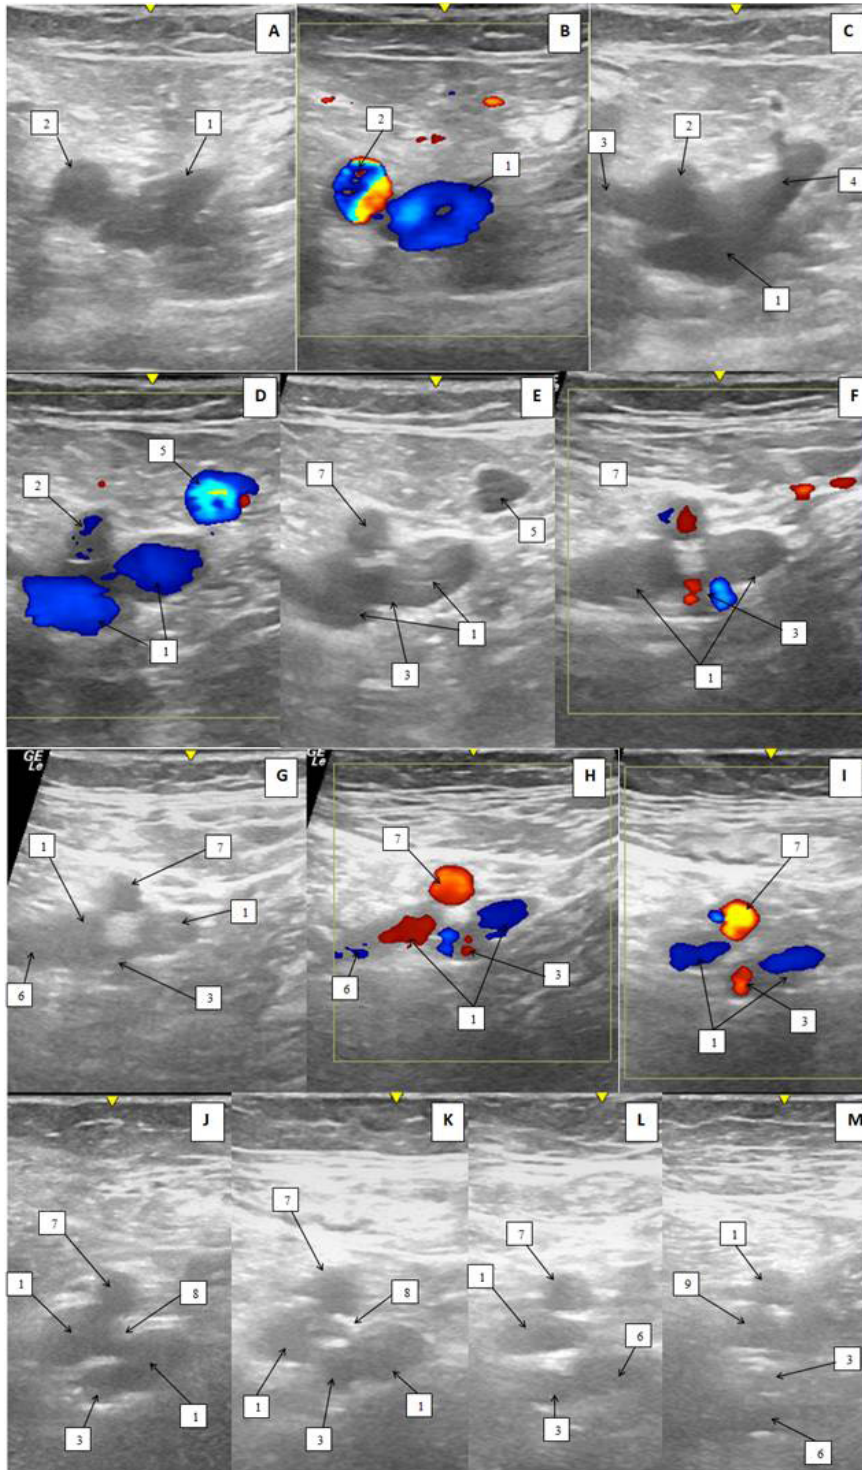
US duplex scan of the vessels of the upper third of thigh on the right of patient K. (two-dimensional, gray scale mode (B-mode) and color Doppler imaging mode; cross-section): (A–B) superiorly the saphenofemoral junction; (C) the level of saphenofemoral junction; (D–M) inferiorly the saphenofemoral junction.
